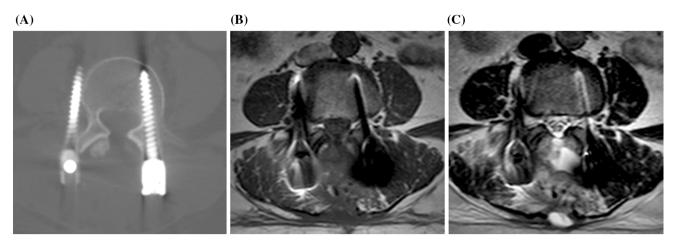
a CT axial section; b, c T1- and T2-weighted axial sections. Right transpedicular screw laterally positioned
